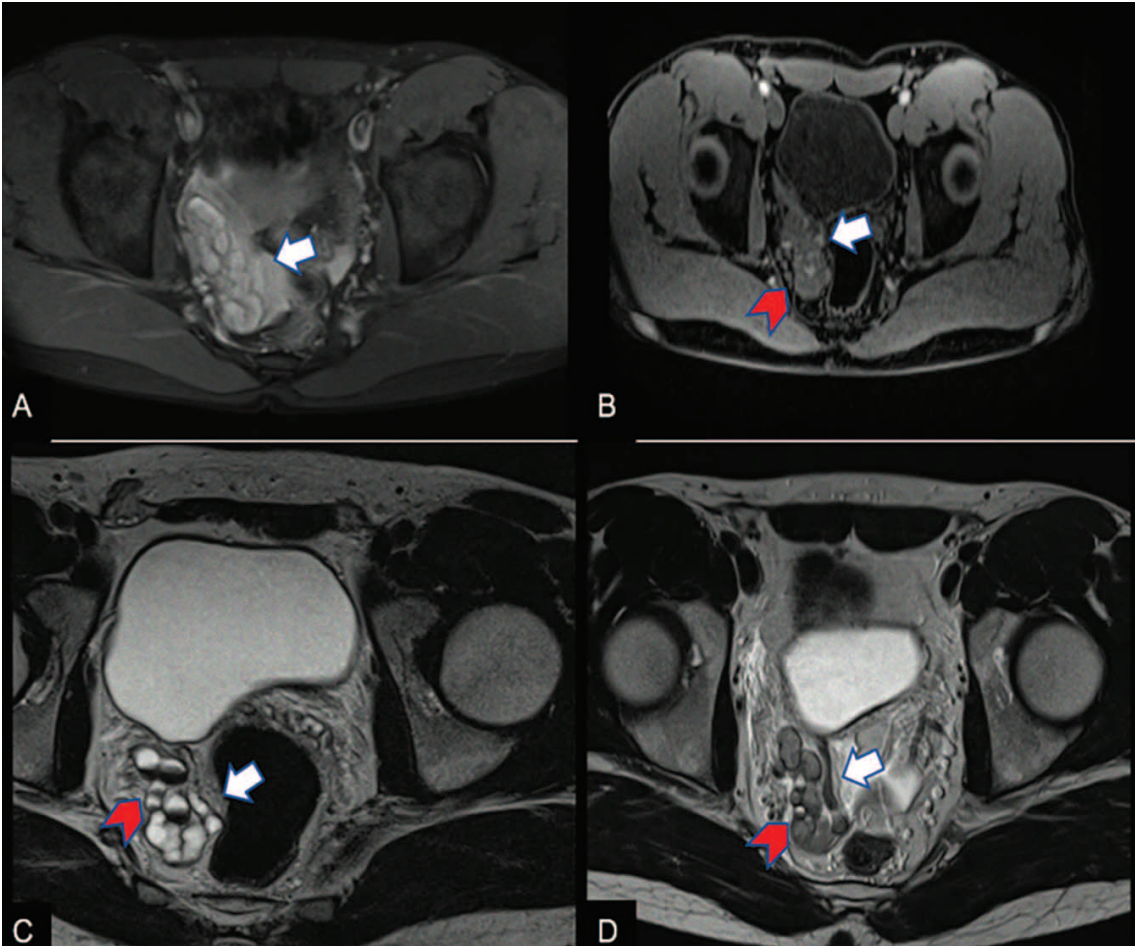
(A, B) Axial T1 and T1 FS MRI: cystic dilatation of tortuous seminal vesicles on the right (white arrow), with a weakly hyperintense signal on T1-weighted images, and fluid levels (red arrow). (C, D) Axial isotropic T2 and routine T2 MRI: dilated tortuous seminal vesicles on the right (white arrow), in the form of T2 hypointense intraluminal content changes with fluid levels (red arrow)
